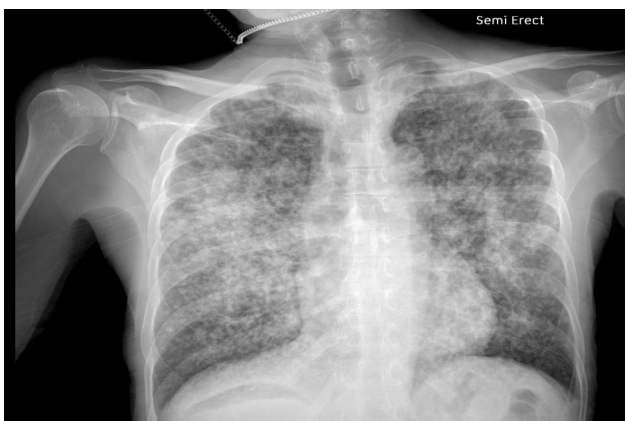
Chest X-ray showing diffuse bilateral reticulonodular opacities.
